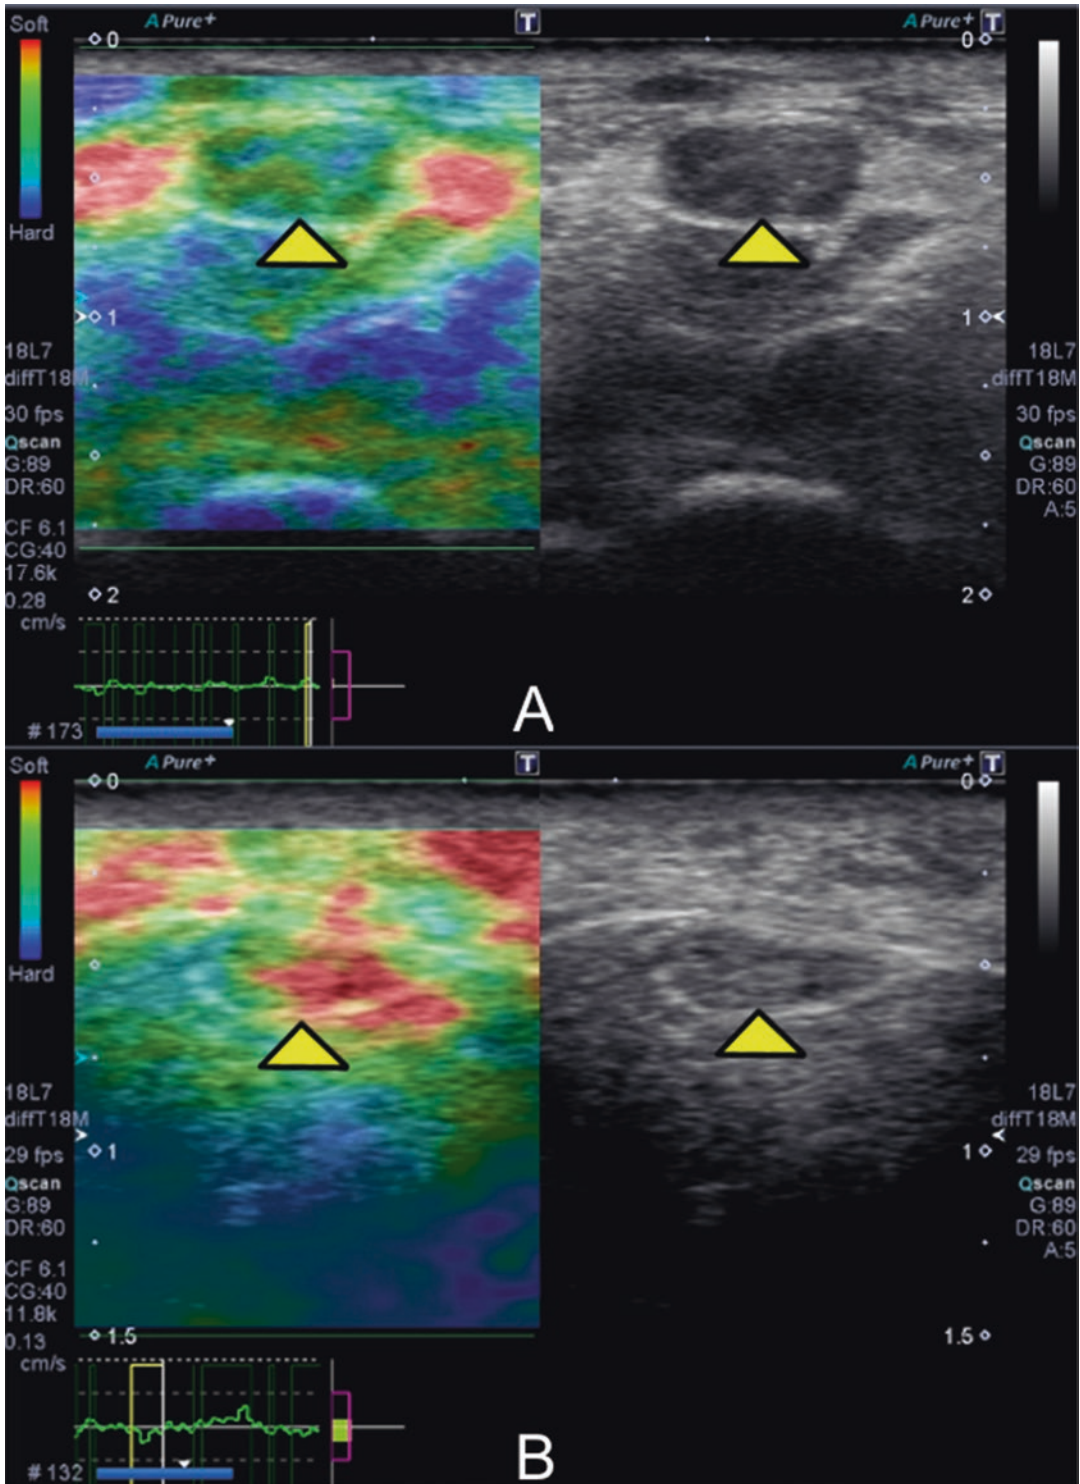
Ultrasound strain elastography—CTS patient (a) with an enlarged median nerve (arrowhead) and color mapping on elastography indicating increased nerve stiffness (blue) compared to a normal asymptomatic patient
